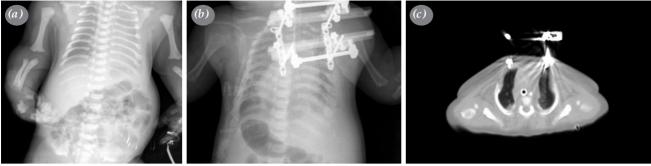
(a) Preoperative chest X-ray of the patient. (b) Chest X-ray immediately after the distractor placement. (c) Thoracic computed tomography scan showing sternal width before extracting fixator.
